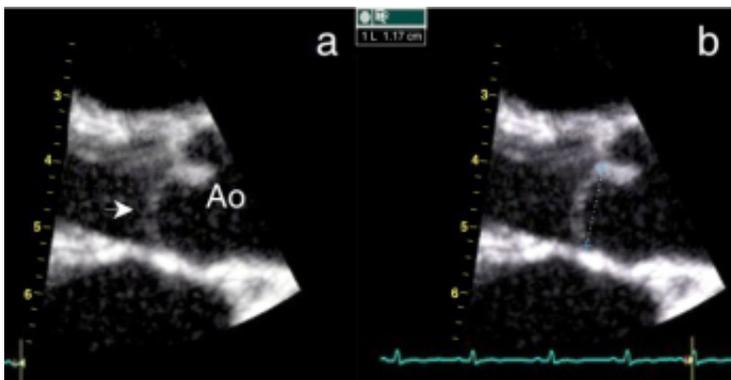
(a) Parasternal long axis image shows prolapse of the noncoronary leaflet of the aorta (arrow). (b) Displacement of the leaflet toward the left ventricular outlet is seen. Ao= aorta.
